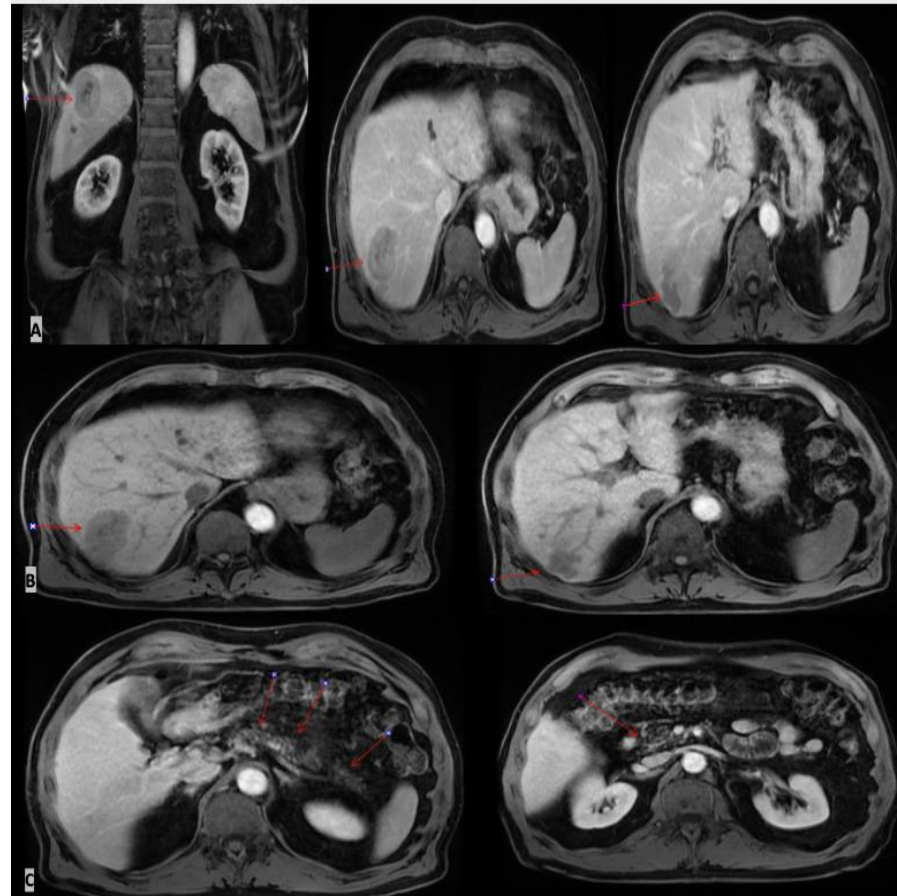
A: Post-contrast T1-weighted MRI; images showing predominantly peripheral enhancement of segment 6/7 hepatic lesion (red arrows). B: Pre-contrast T1-weighted MRI; images showing predominantly peripheral enhancement of segment 6/7 hepatic lesion (red arrows). C: Post-contrast T1-weighted MRI; Left image marks pancreatic body and tail, Right image marks the uncinata/head, does not show any lesion and is completely normal.
